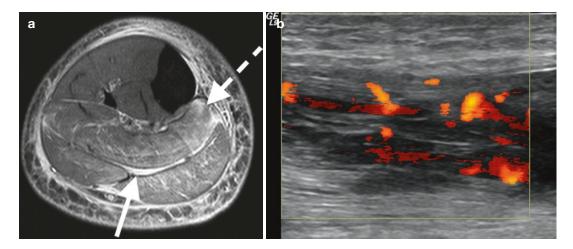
Pyomyositis: (a) axial T2FS MRI in patient with pyomyositis with diffuse increased muscular edema (*dashed arrow*) and fascial fluid (*arrow*) and (b)
